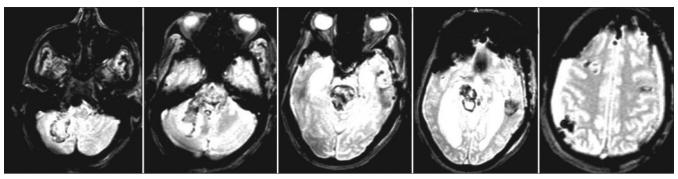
Postoperative MRI gradient images showing blooming of the lesions in Figure 2 suggestive of hemorrhages
